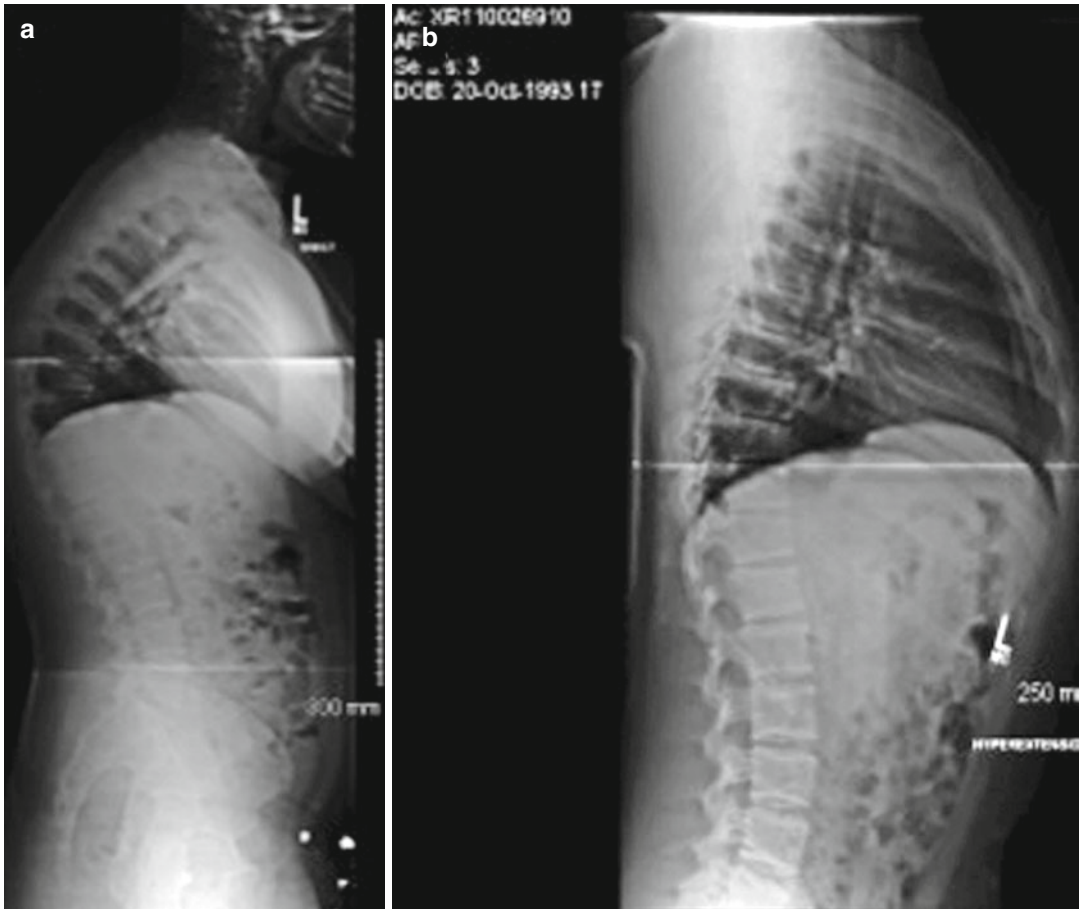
(a) Lateral radiograph of a boy with Scheuermann kyphosis with a 75° kyphosis. (b) Lateral hyperextension radiograph over a bolster showing good correction of the kyphosis to 28°
